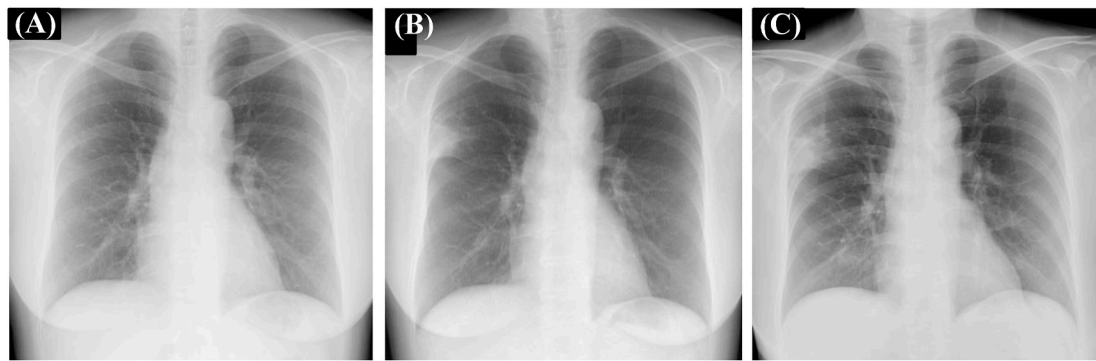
(A) Chest X-ray at first presentation showing subtle nodular infiltrates in the right middle lung field. (B) Chest X-ray showing infiltration shadows in the right middle lung field in the beginning of December 2018. (C) Chest X-ray showing the expansion of infiltrating shadows in the right upper lung after 4 days of empirical intravenous antibiotic therapy.
